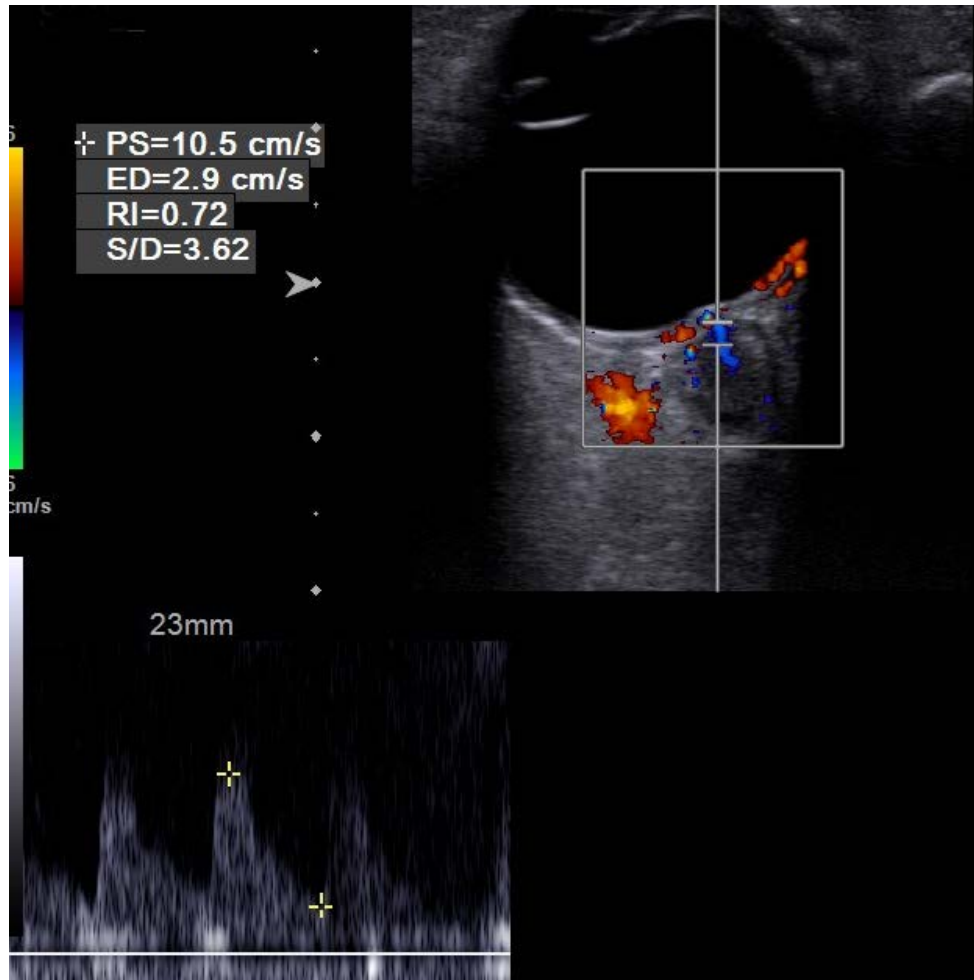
Doppler Ultrasonography of the Central Retinal Artery in a Patient with Idiopathic Intracranial Hypertension
